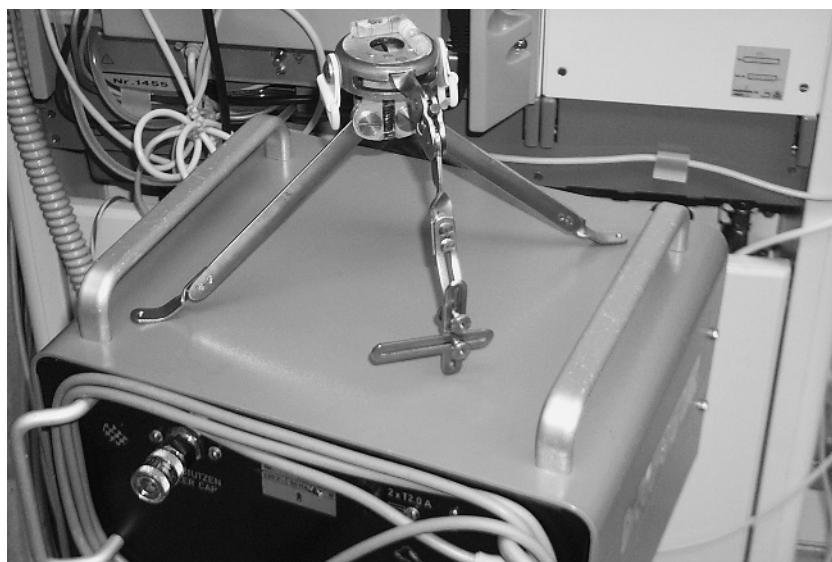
Tripod used to establish the pelvic reference frame parallel to the table for a patient undergoing radiography in the supine position.
